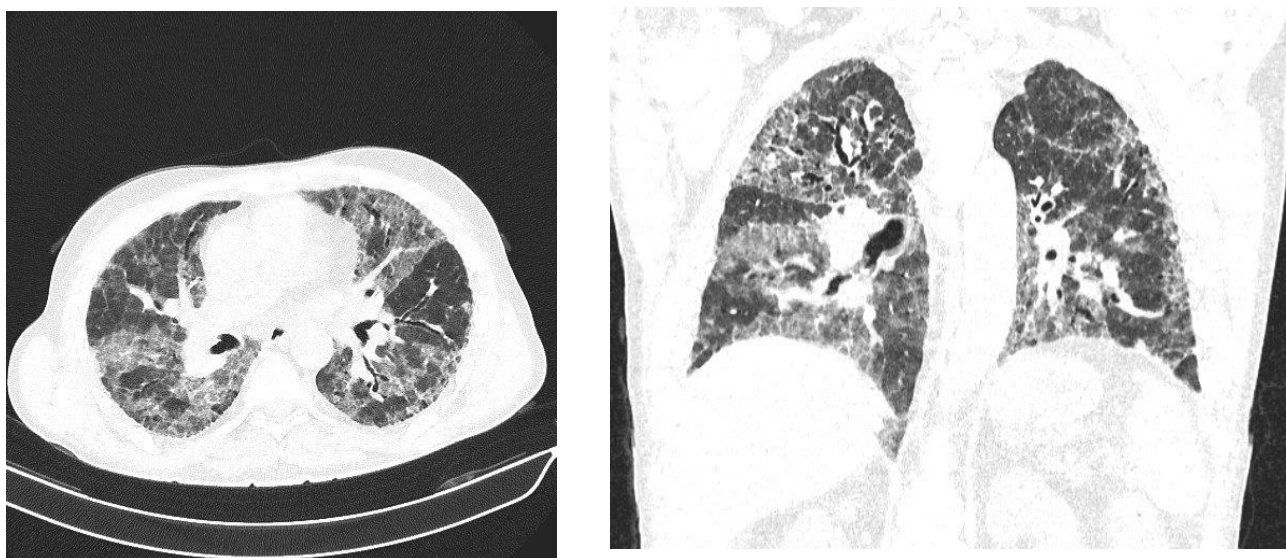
Computed tomography (Left) -axial plane, (Right)-coronal plane
